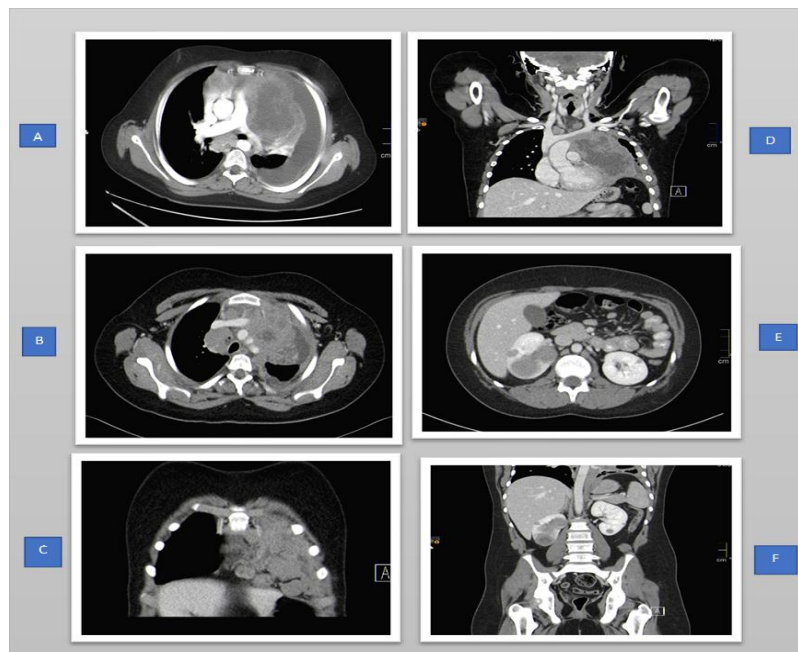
CT scan of neck and chest (A) Large heterogenous soft tissue mass occupying anterior mediastinum and causing shift of mediastinal structures to other side, measuring 12x11x8 cm.(B)mass shows hypodense areas of necrosis with mild left pleural effusion.(C)Multiple enlarged cardio phrenic L.N and minimal pericardial effusion. (D)Multiple large mediastinal lymph node the largest seen in superior mediastinum 2.5x1.7 cm ,right paratracheal measuring 3.6x2.4 cm, subcarinal 3.5x 2.3cm, left supradiaphragmatic 3.1x1.6 cm.(E,F) hepatomegaly and multiple bilateral renal hypodense masses largest 3.6x3.4 and 3.8x3.3cm².
